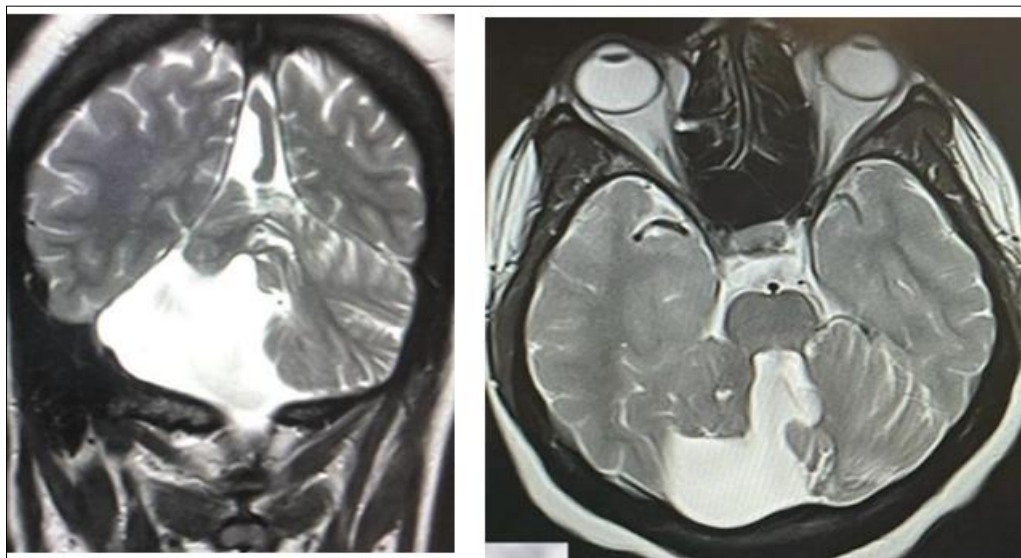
Coronal and axial T2-weighted images showing partial absence of the right cerebellum
